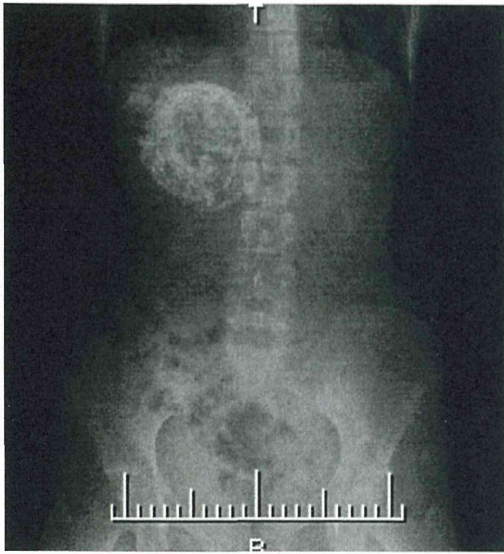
Abdominal X-ray, showing a 13×10 cm tumor with calcification in the right upper region
